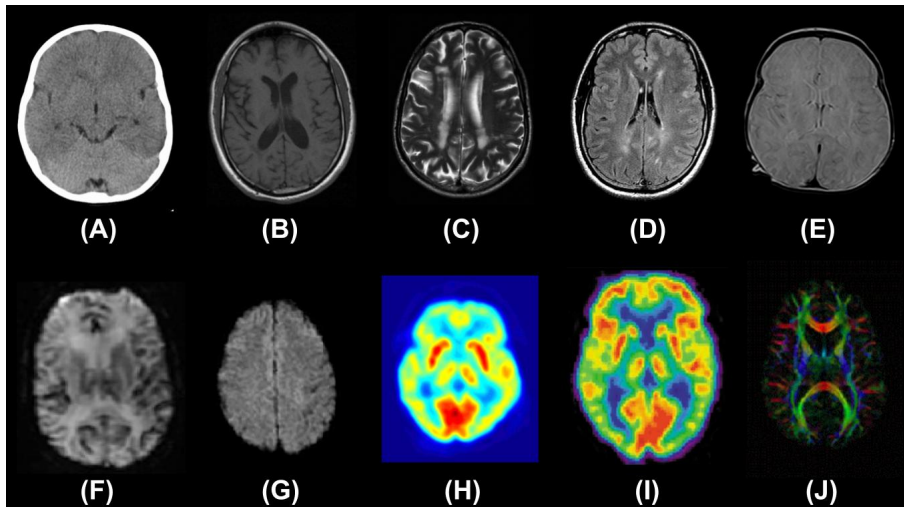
Example of various NeuroImaging Modalities. (A) CT (B) T1 MRI (C) T2 MRI (D) FLAIR MRI (E) PD MRI (F) PWI MRI (G) DWI MRI (H) SPECT (I) PET (J) DTI
